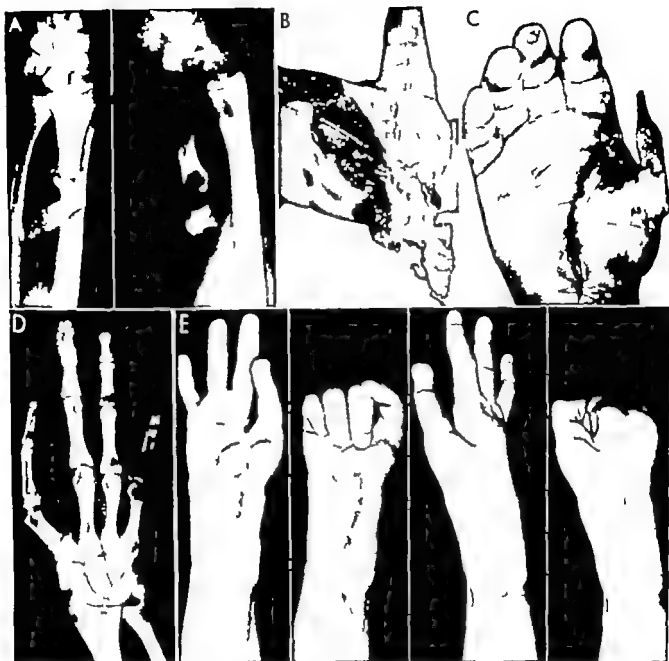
A, subcutaneous dislocation of phalanges of thumb along with first metacarpal. The bones were displaced under the skin over the volar aspect of the wrist when the hand was crushed in a pressing machine. B, appearance of hand after the phalanges had been removed from the dislocated position; skin of thumb intact. C, gangrene of thumb 3 weeks after injury. Although open reduction of the bones had been accomplished a few hours after injury, circulation to the soft parts did not survive and amputation of the thumb at the base of the first metacarpal was necessary. D, x-ray view and E, appearance of hand showing end result after amputation of thumb and transposition of forefinger to position of thumb.
